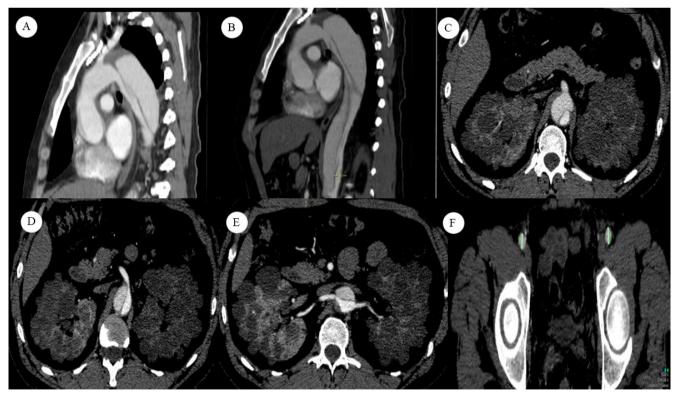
A & B) The preoperative computed tomography (CT) angiograms are presented herein. The preoperative CT angiogram shows a Type B aortic dissection with the entry tear close to the left subclavian artery, C) With the significant compression of the true lumen. The celiac artery originates from the false lumen, D) The superior mesenteric artery originates from the true lumen, E) Both renal arteries originate from the true lumen. F) The right common femoral artery is 7.8 mm in diameter, and the left common femoral artery is 8.4 mm in diameter.
